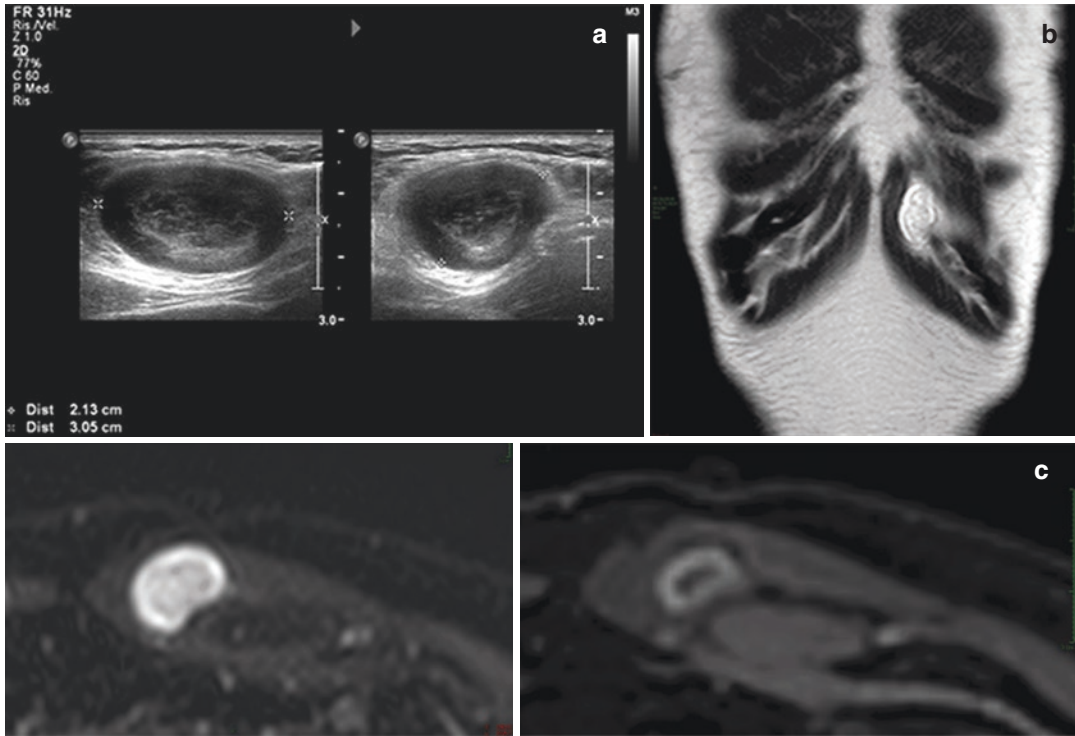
Parasternal neurofibroma in neurofibromatosis. With an ultrasound, the palpable swelling of the thoracic wall showed an oval, unevenly hypoechoic lesion with regular contours of 2.2 × 3.4 cm (a). MRI: Coronal acquisition T2w (b); axial acquisition T2w SPAIR(c);
